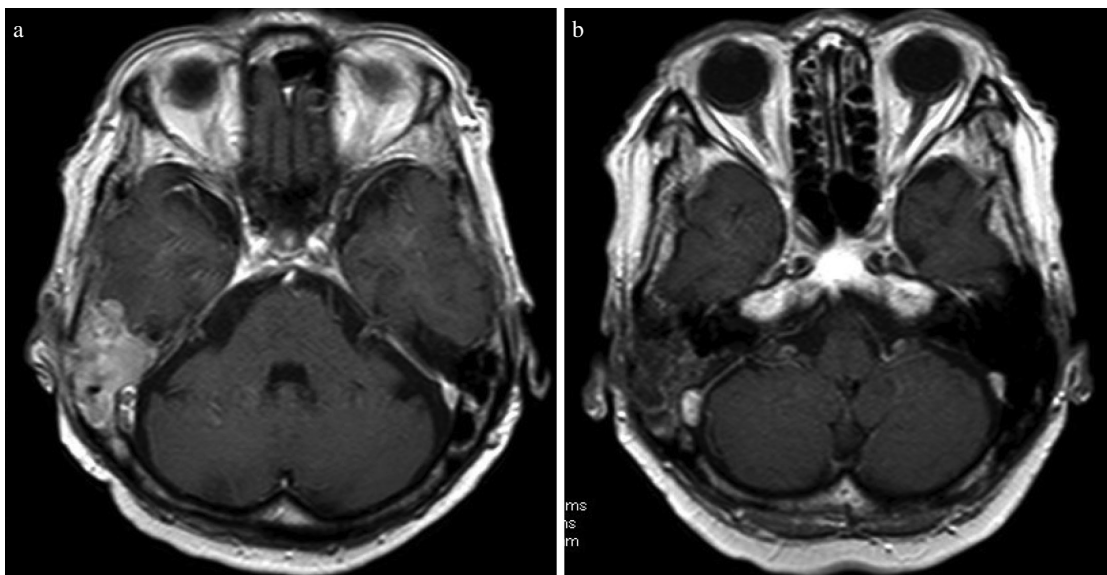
(a) Follow-up head MRI at 31 months showed local recurrence in the right mastoid air cell. (b) Follow-up head MRI at 45 months showed cystic degeneration of the recurrent lesion.
